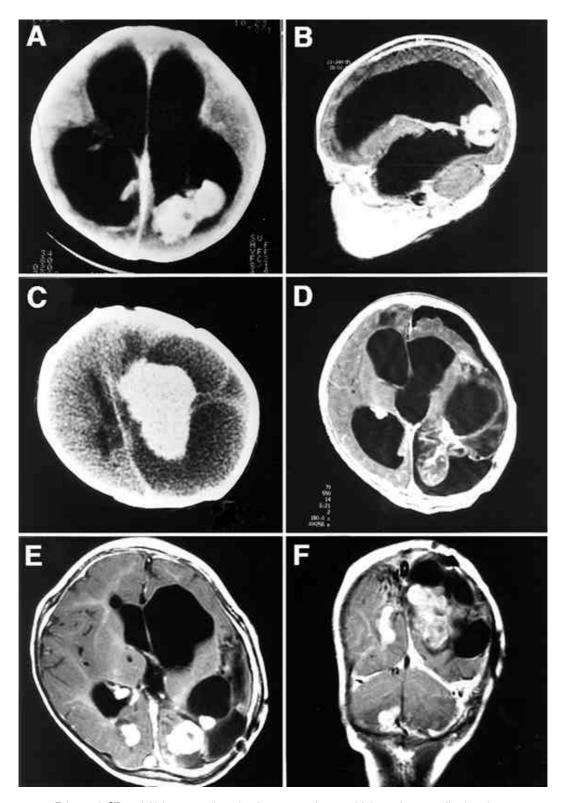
Enhanced CT at initial presentation showing a round to ovoid hyperdense, well-enhancing, $3\times2\times2$ cm-sized mass in the trigone of the left lateral ventricle and a marked dilatation of all the ventricles (A); sagittal T₁ weighted (T₁W) enhanced MRI showing the lobulated mass which has a contact with the posterior wall of the lateral ventricle and the choroid plexus of the trigone (B); axial enhanced CT taken at one month after admission showing the markedly enlarged mass (C); axial T₁W enhanced MRI after operation showing the residual tumor adjacent to the thalamus (D); T₁W enhanced MRI taken at 11 months after surgery revealing multiple seeding of the tumor through the cerebrospinal fluid pathway (E and F).
